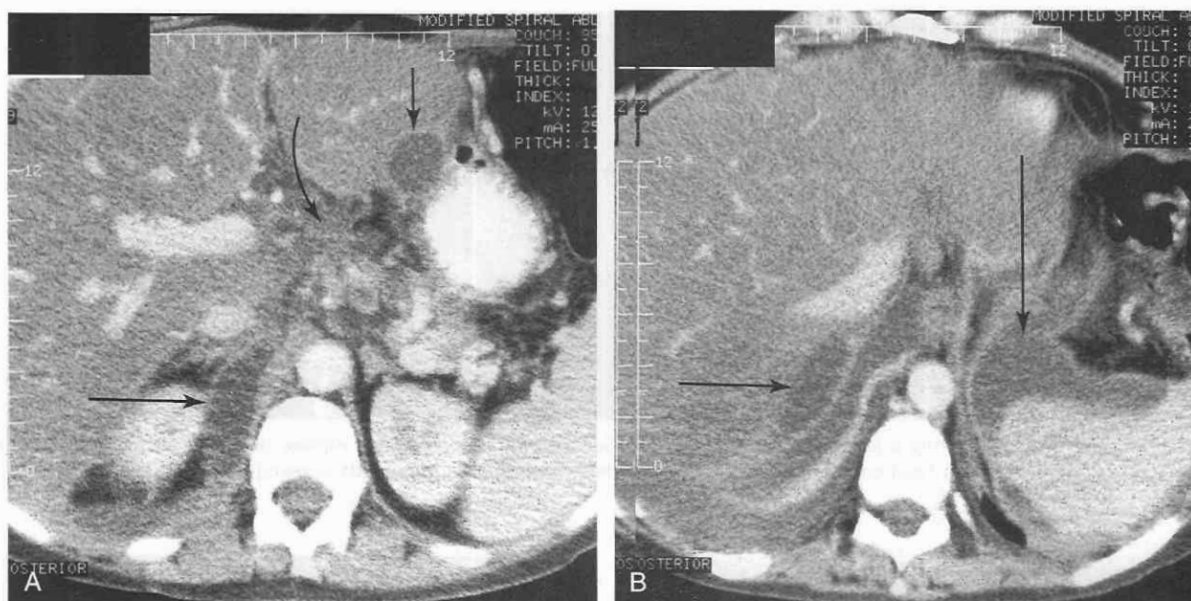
A, CT scan taken at a high level shows cystic fluid in the subcapsular region of the liver (*arrow*), the porta hepatis (*curved arrow*), and the retroperitoneum behind the right kidney (*horizontal arrow*). B, Scan taken at a slightly different level shows inflammatory fluid around the spleen (*vertical arrow*) and bare area of the liver (*horizontal arrow*) by the adrenal gland.
